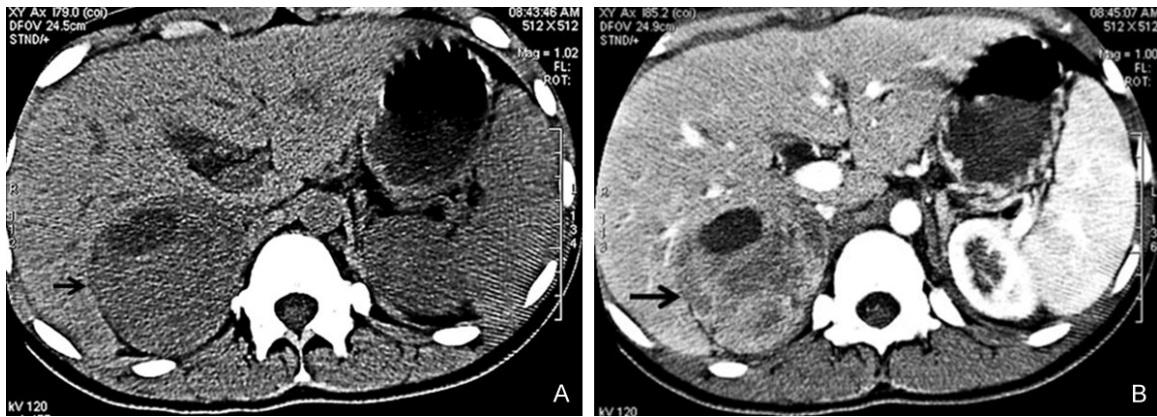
Computed tomography (CT) images of right adrenal mass. A: Unenhanced axial CT images shows a un-even mass (black arrow) about 8.5 cm×6.5 cm×6.5 cm with intact capsule located at the right adrenal gland. B: Enhanced axial CT images shows a round-like mass (black arrow) with cystic parts in addition to enhancing solid parts located at the right adrenal gland, consistent with adrenal pheochromocytoma.
